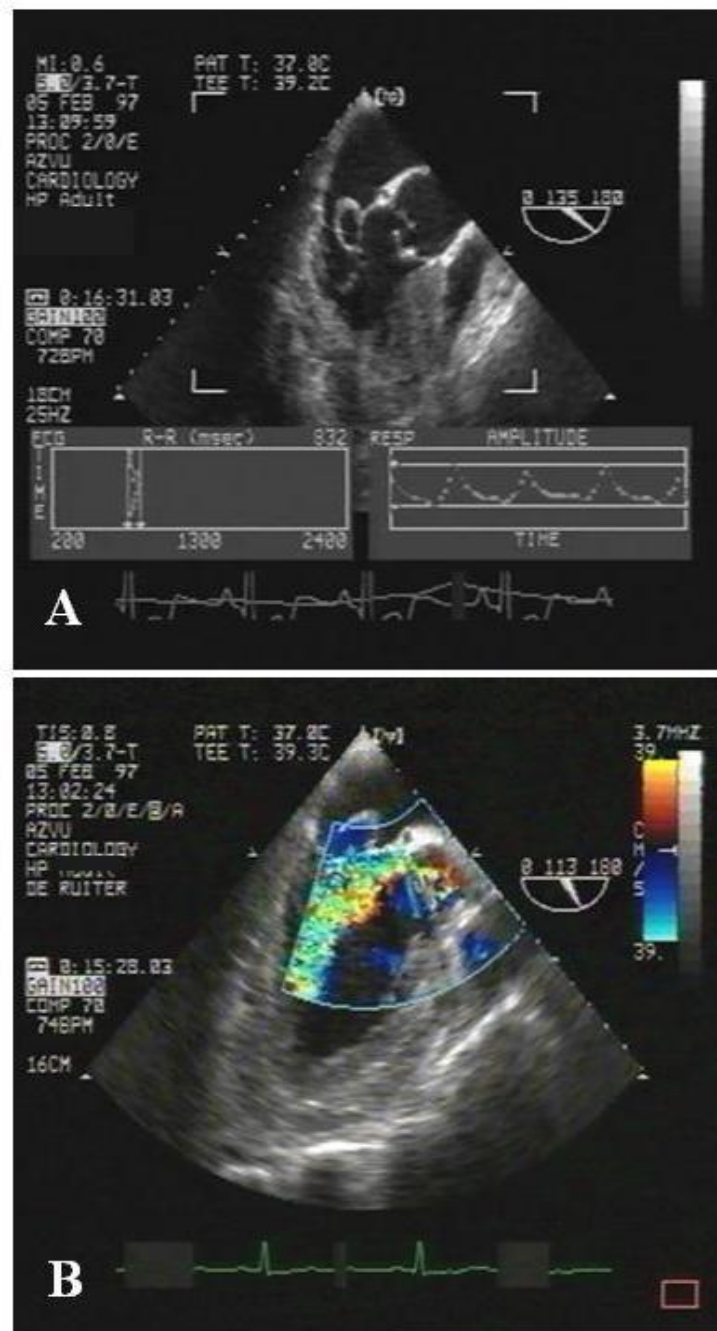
Multiplane transesophageal echocardiographic views. A, Aneurysm located on the anterior mitral leaflet and prolapsed aortic valve. B, Color Doppler imaging reveals the regurgitant jet originating from the prolapsed aortic valve. Note the direction of the jet toward the anterior mitral leaflet.
